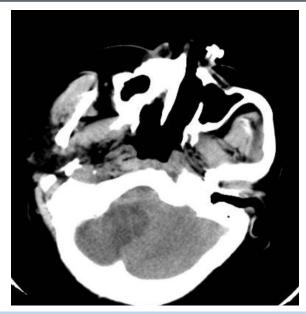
CT brain without contrast is showing occipital ischemia infarction.
